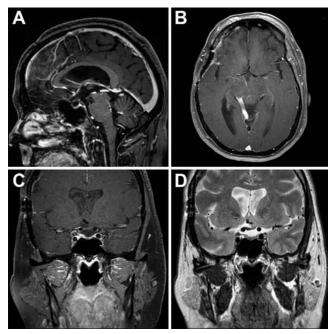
Postoperative sagittal (A), axial (B), and coronal (C) post-Gd T1-weighted and coronal T2-weighted (D) MR images demonstrating complete resection of the optic chiasm CM. The optic chiasm is decompressed and well visualized on the coronal views (C and D). The associated venous angioma is again shown in the right posterolateral aspect of the mesencephalon (B).
